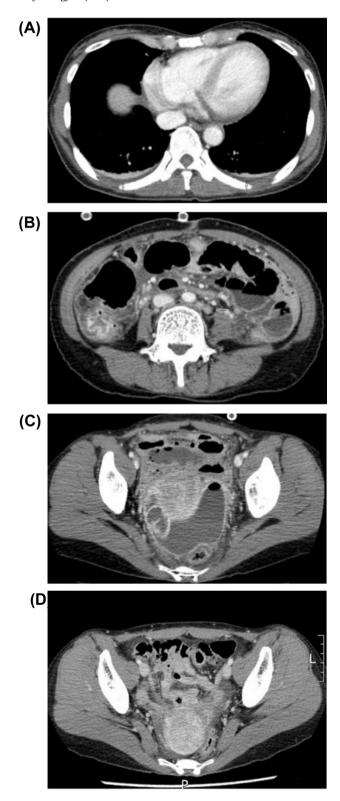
Computed tomography scan showing (A) pleural effusion, (B) lymphadenopathy and ascites, and (C) pelvic inflammation prior to treatment, and (D) improving state after treatment.
